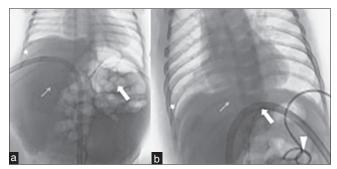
(a) X-ray abdomen and chest showing both ureteric catheters in normal position and blunting of right costo-phrenic angle due to hydrothorax (thin arrow: tip of right ureteric catheter, thick arrow: tip of left ureteric catheter, asterix: blunting of right costo-phrenic angle), (b) X-ray abdomen and chest showing migrated ureteric catheters and clearing of right costo-phrenic angle after tapping of fluid (thin arrow: tip of right ureteric catheter in right thoracic cavity, thick arrow: tip of left ureteric catheter below left diaphragm, asterix: clearing of right costo-phrenic angle, arrow head: Pigtail catheter in left renal pelvis)
